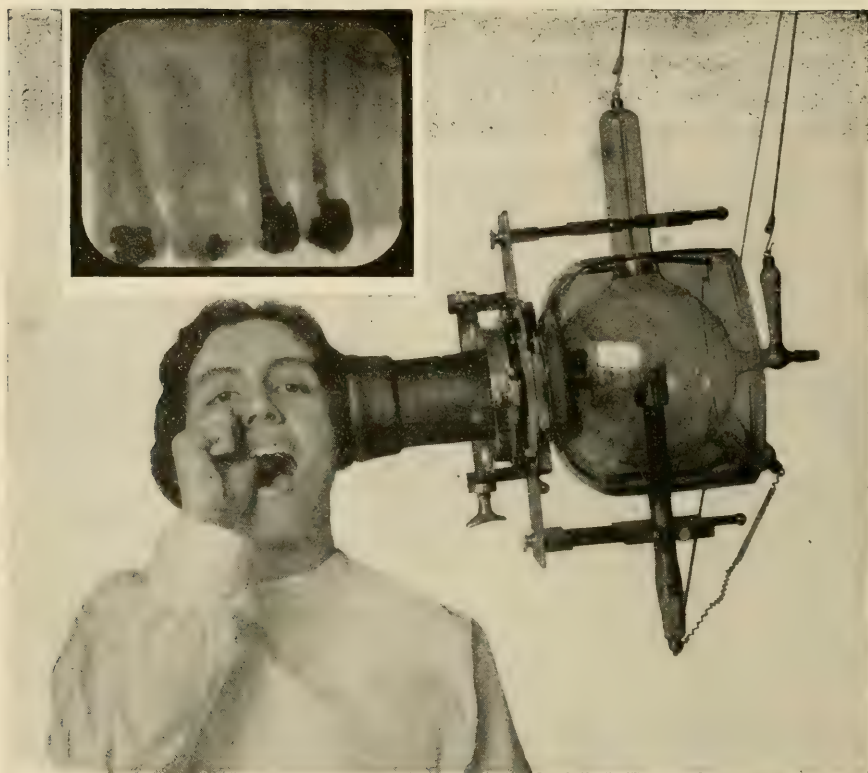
Incorrect pose for radiographing the upper bicusps and molars, and a radiograph made from the pose.
